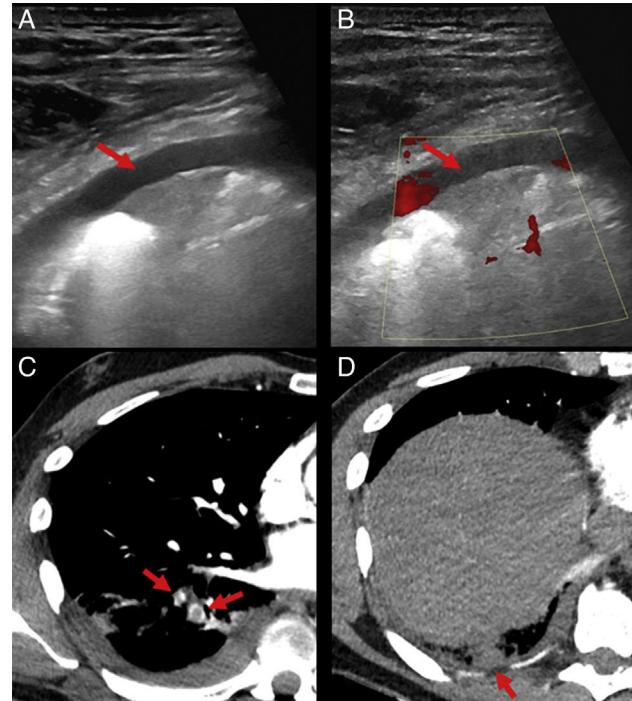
Chest ultrasound and computed tomography showing a filling defect in the segmental arteries of the RLL, and pleural-based, triangular subpleural consolidation, diagnosed as pulmonary thromboembolism with pulmonary infarction.
